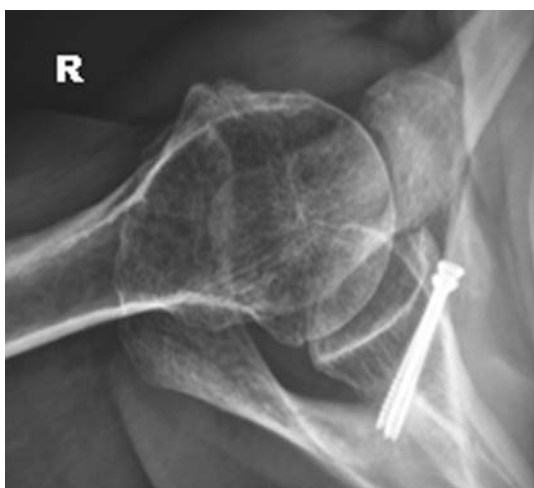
Axillary radiograph of the patient shown in Figs. 1, 2, 3 and 4 postoperatively
